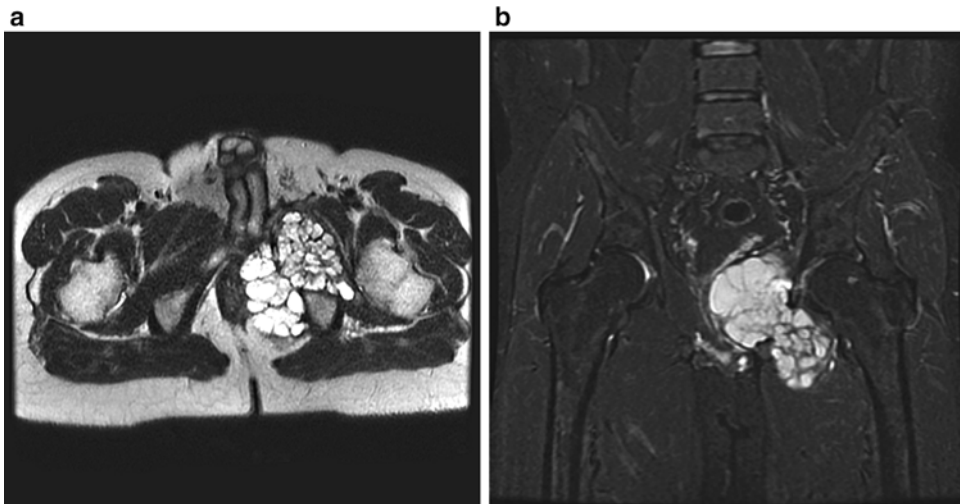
(a–b) Axial T2 and coronal STIR magnetic resonance images of a large pelvic chondrosarcoma, displaying its difficult anatomic location that poses challenge
